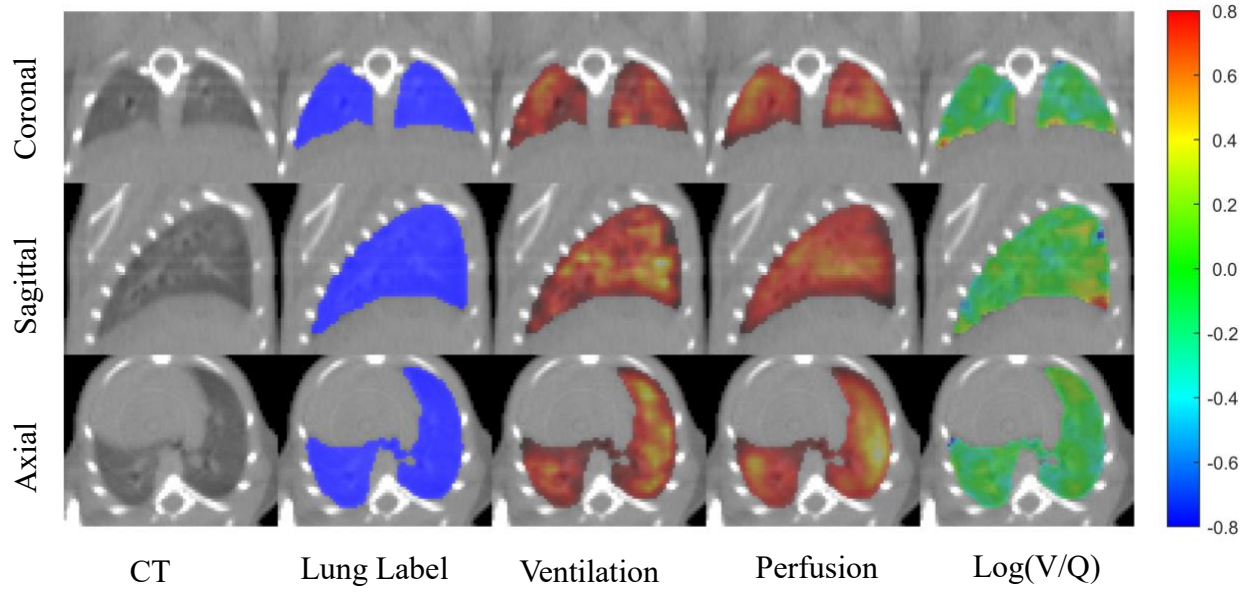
Representative image showing axial, coronal, and sagittal planes of section of SPECT-CT imaging. CT scans were used to create a lung label (blue, second column from left) on which relative ventilation (V), relative perfusion (Q), and  $\log(V/Q)$  were overlaid.
